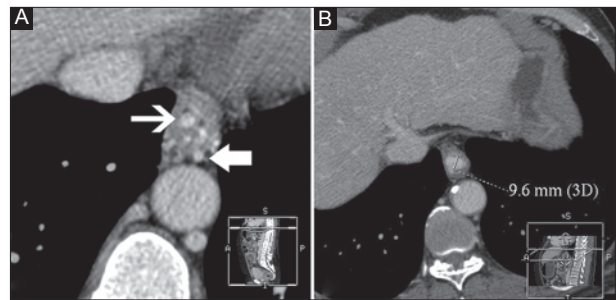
True positive computed tomography scans for esophageal varices. (A) Small submucosal (thin arrow) and subserosal (thick arrow) esophageal varices. (B) Big submucosal esophageal varices
